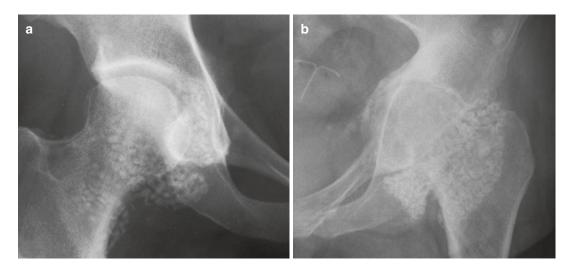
(a–b) Primary (a) and secondary (b) synovial chondromatosis of the hip in two different patients: (a) plain radiograph of the right hip in a 36-year-old woman. Notice the presence of rice grain-like ossified nodules in the right hip joint. In primary synovial chondromatosis, the joint space is normal or can be even enlarged. Furthermore, the nodules are typically small and of uniform size in the primary form, whereas they are often
